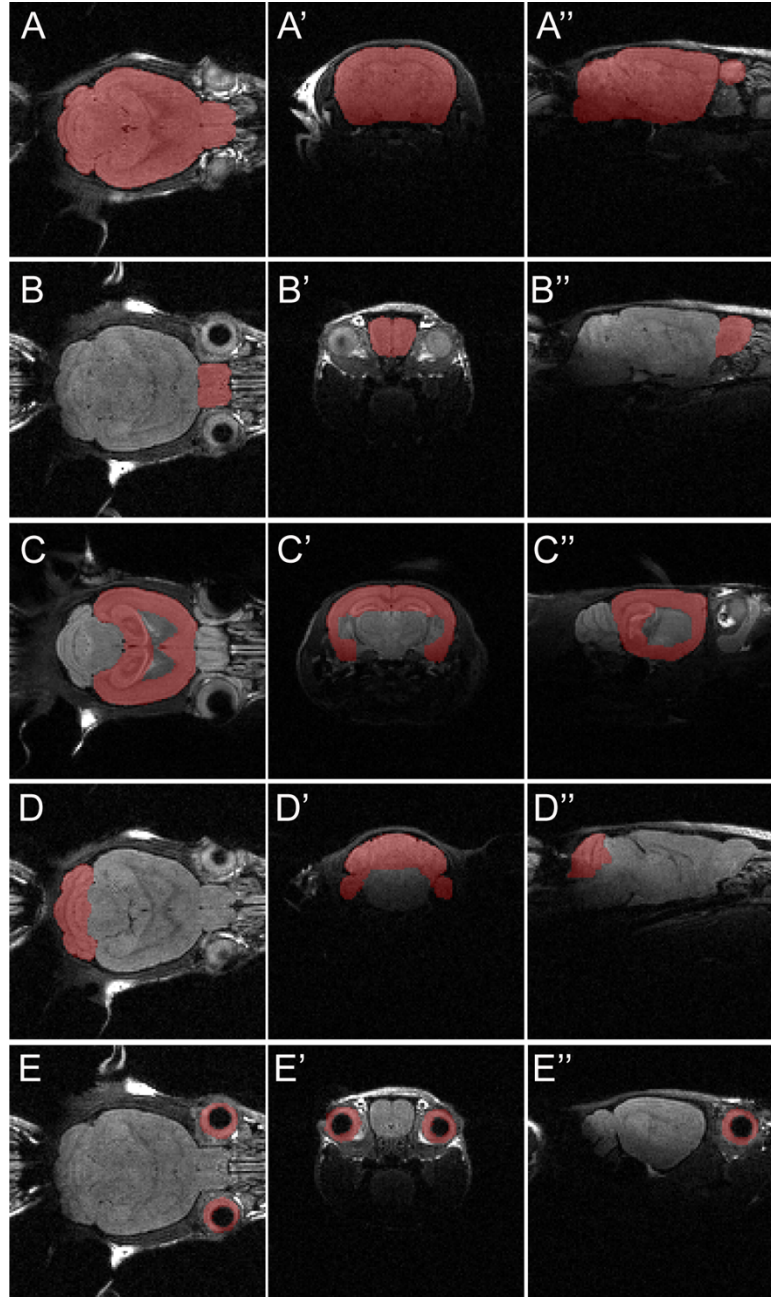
S.1: Representation of MRI masking. A-E Examples of how masking was conducted for MRI data for each structure we examined. All three axes are represented for each structure. A Whole brain. B Olfactory bulbs. C Cortex. D Cerebellum. E Eyes
